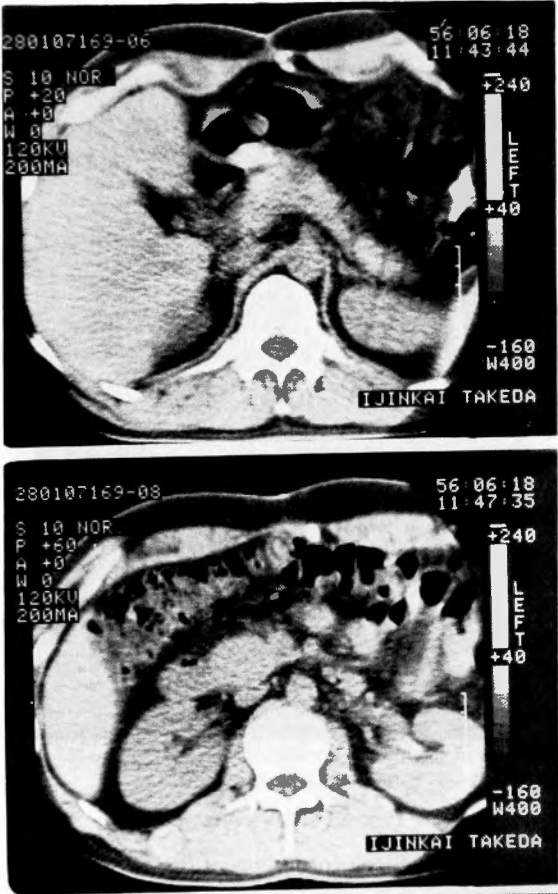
Abdominal CT showing calcified mass in the median anterior abdominal wall
